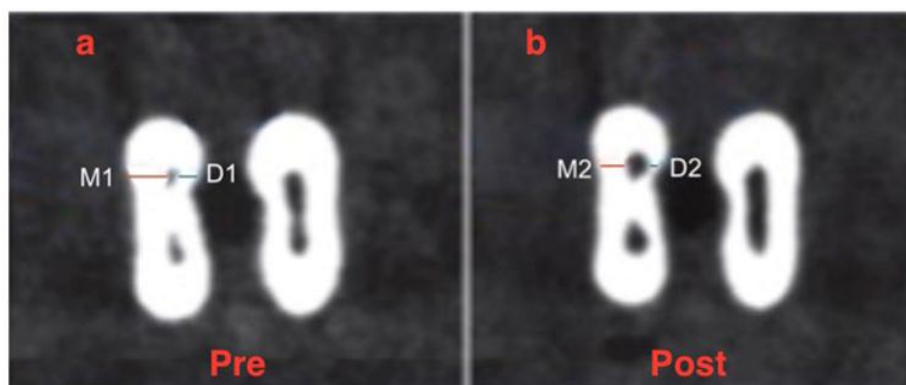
Scan image of the sample, (a) Pre-instrumentation and (b) post-instrumentation CBCT images with markings showing points of measurements used for determination of canal transportation and centering ratio
